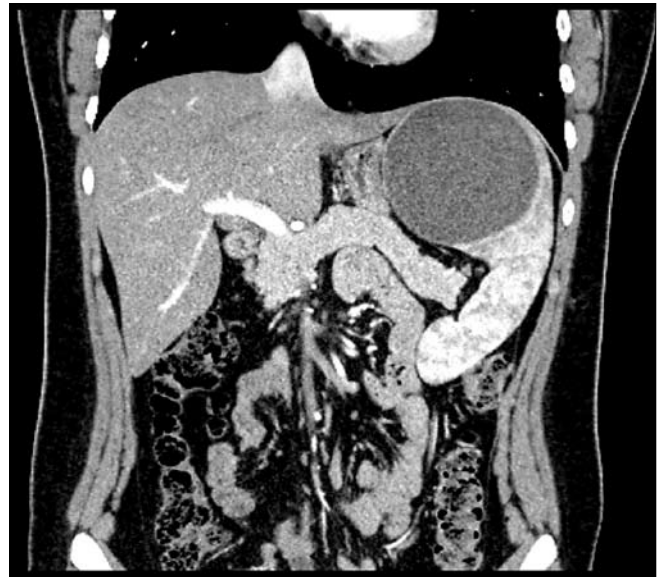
CT scan showing a large splenic cyst.
